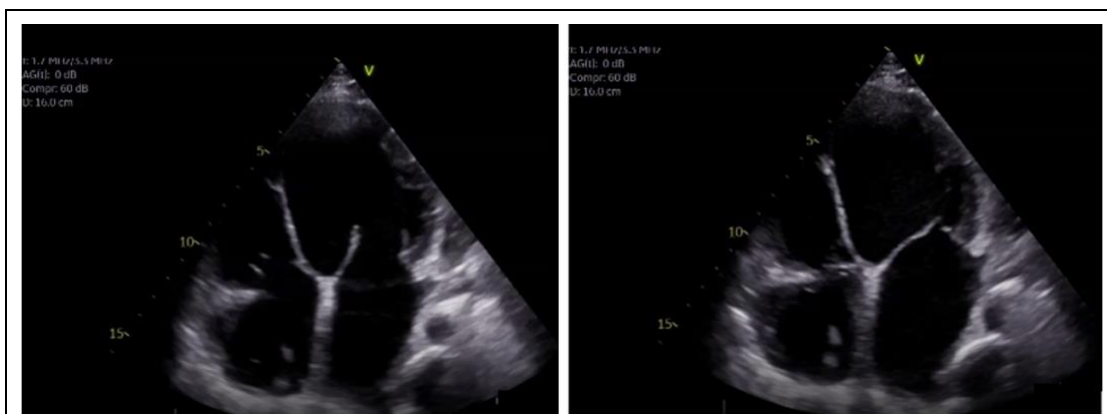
Transthoracic echocardiogram four-chamber view six months after discharge (end-diastolic image on the left, end-systolic image on the right) demonstrating dilated left ventricle with severely impaired ejection fraction and very thin interventricular septum (3 mm).
